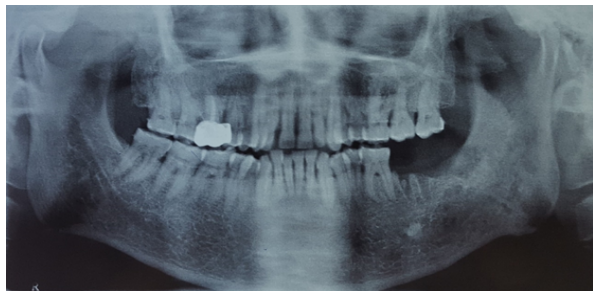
Preoperative Orthopantomogram Showing Loss Of Trabeculation In Periapical Region Of Extracted Left Mandibular Second And Third Molar
